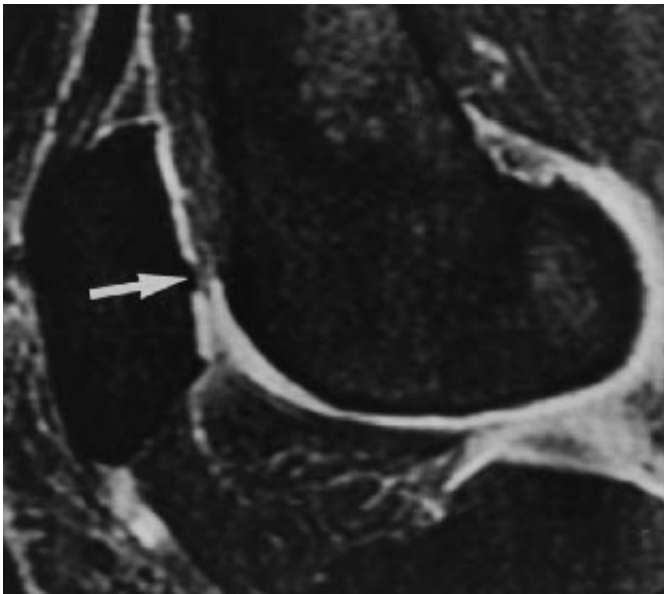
50-year-old woman with central osteophyte (arrow) at lateral facet of patella on sagittal fat-suppressed three-dimensional spoiled gradient-echo MR image (TR/TE, 40/6; flip angle, 40°). This is one of only three of 35 central osteophytes not covered by thin layer of high signal intensity.
